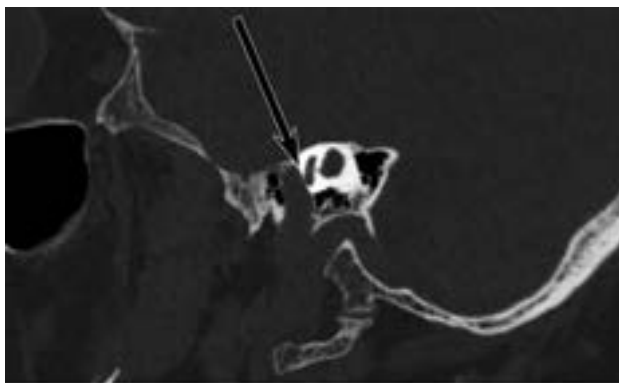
The importance of multiplanar oblique reformats for the diagnosis of cochlear-facial dehiscence. Axial CT image (A) shows an apparent dehiscence (arrow) between the middle turn of the cochlea and the labyrinthine segment of the facial nerve. Sagittal reformatted image (B) appears to confirm the dehiscence (arrow). However, multiple oblique reformats along the basal turn of the cochlea (C) reveal that the bone between the cochlea and the facial canal (arrow) is thin but intact.
